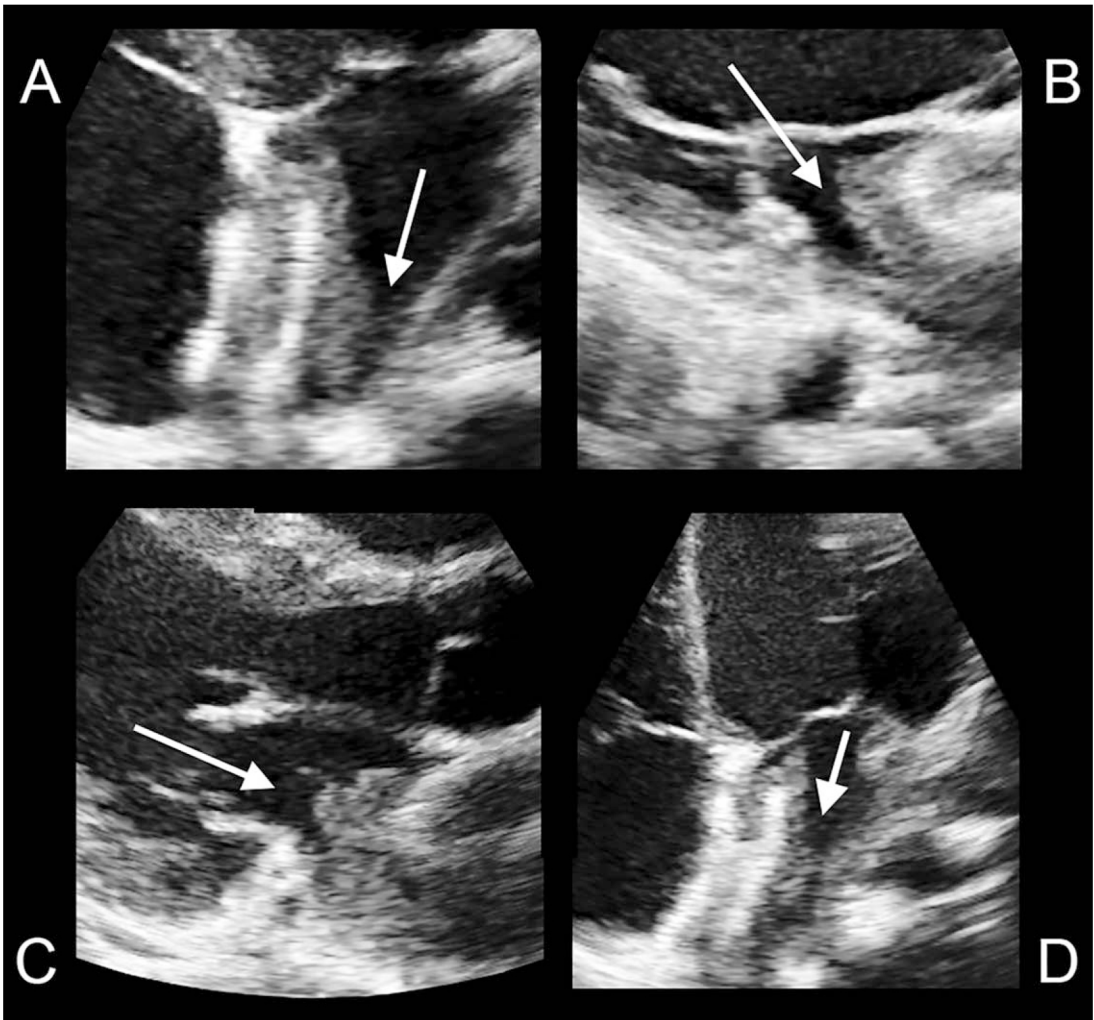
Transthoracic echocardiographic images. Apical four chamber view shows thick panus on left side of ASO (arrow, A). Parasternal long-axis view shows hyperechogenic vegetation on left side of ASO (arrows, B and C). Decreasing in size of vegetation after 6 weeks antibiotic treatment (arrow, D).
